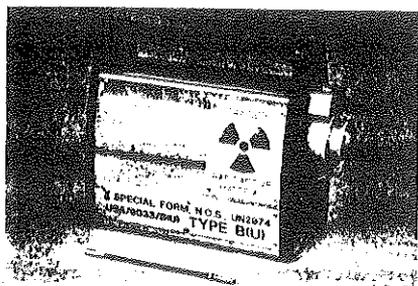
Amertest container with a radiography source.
